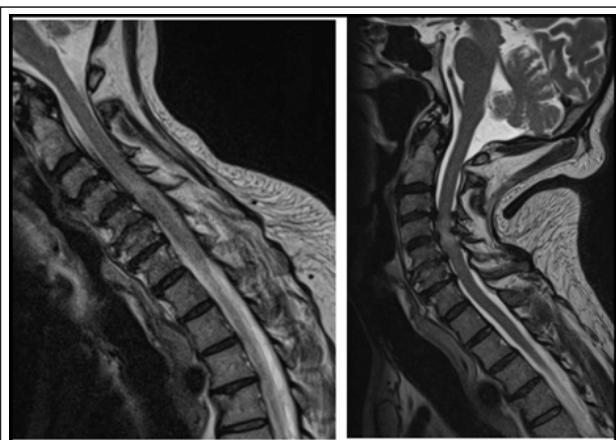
The dMRI shows a posterior buckling of the ligamentum flavum along with edema of the spinal cord in extension that is not apparent on an MRI taken in flexion.
